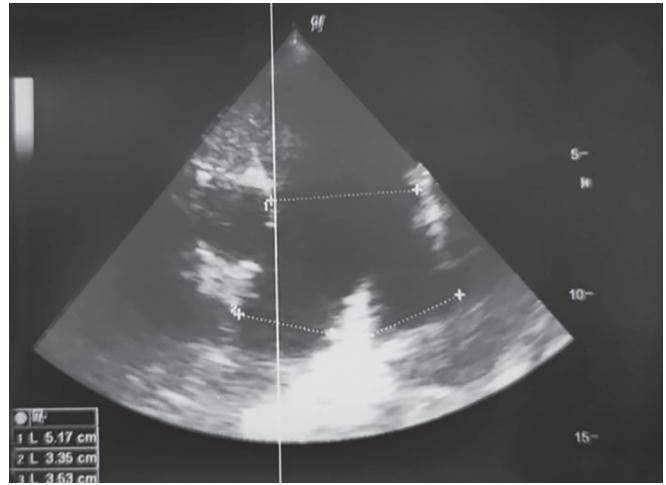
Echocardiography short axis view at the base of the heart showing massive dilatation of main pulmonary artery and its branches
